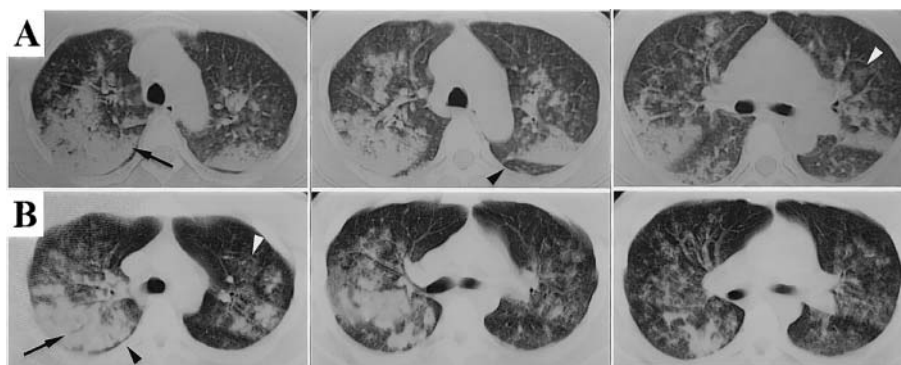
CT scan of the chest of spray-induced patients on admission (Day 2).
